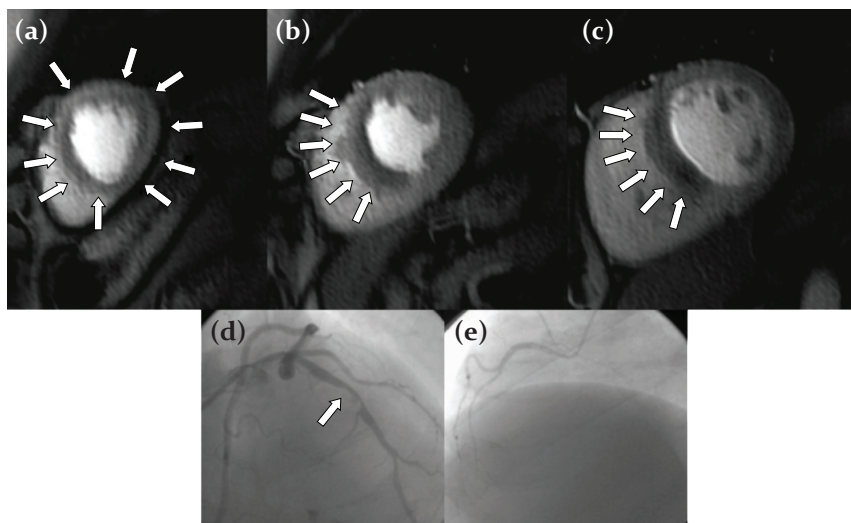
k-t SENSE with SENSE training*: CMR perfusion images acquired during adenosine stress in a patient with suspected CAD shows a circular perfusion defect in the apical slice (a), and anterior, anteroseptal and inferoseptal defects in equatorial and basal slices (b, c). X-ray coronary angiography confirmed a high degree stenosis of the left anterior descending artery (d; arrow) and a small right coronary artery (e)
